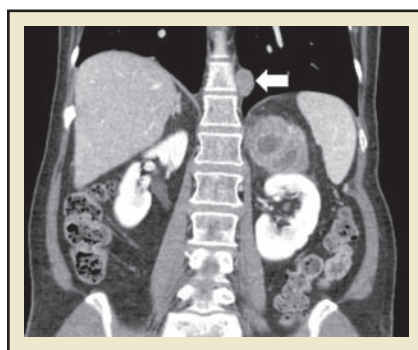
Computed tomography scan with contrast showing a left adrenal lesion along with left thoracic paraspinal nodule (arrow).
